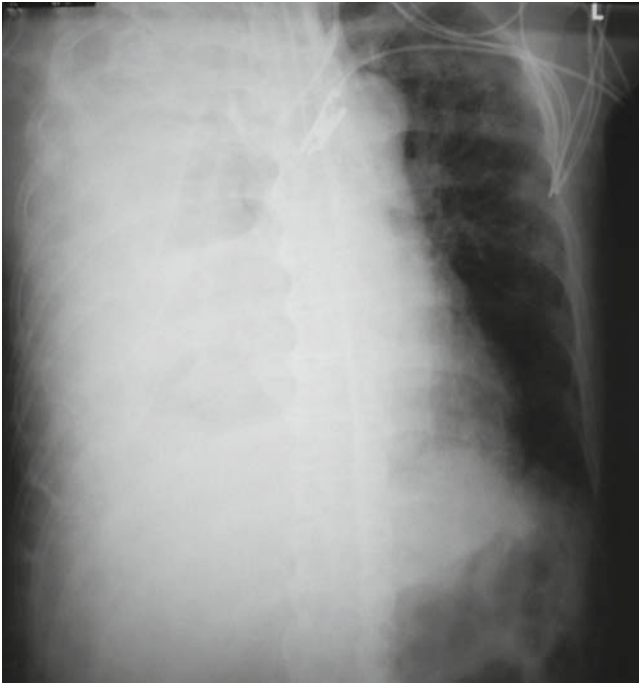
Emergency chest radiograph shows a significant hemothorax
